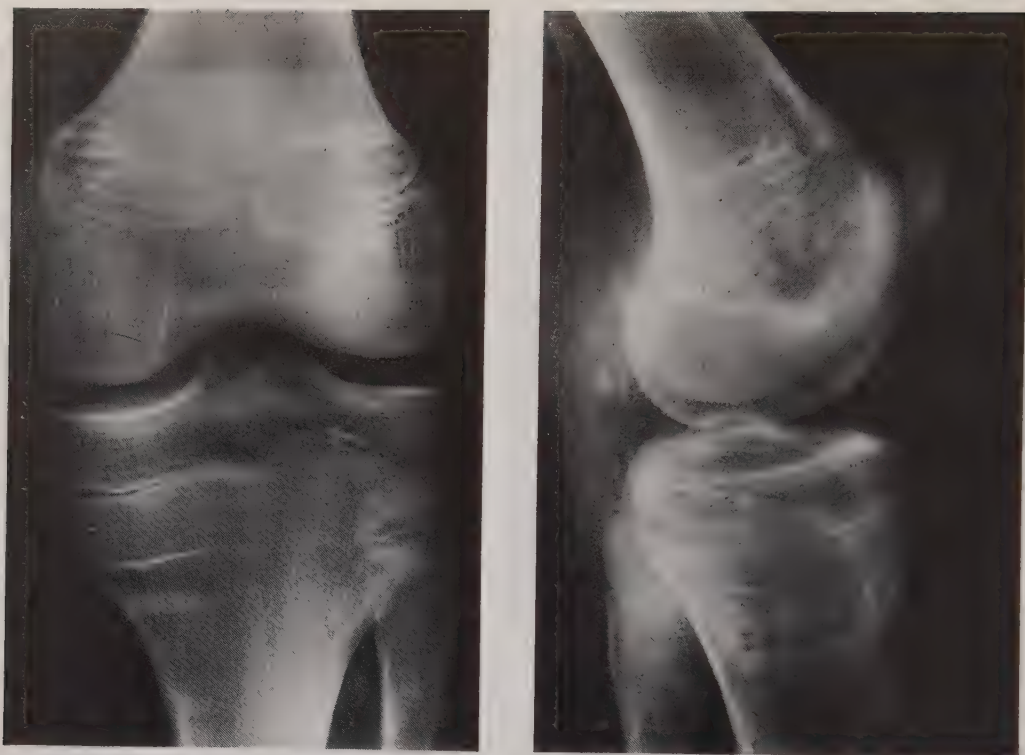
a and b. Case 2. Standard radiographs of left knee after extraction of staples in distal femur (9 months after extraction of staples in proximal tibia). a) AP view; b) lateral view.
